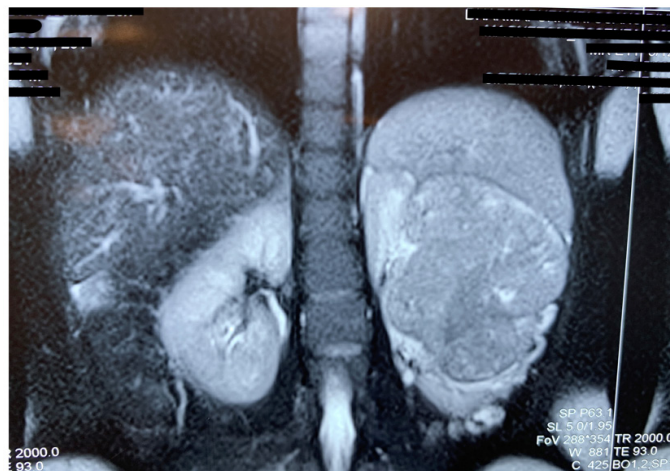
MRI image showing renal mass and singleton live in-traiterine pregnancy of 34 weeks.
